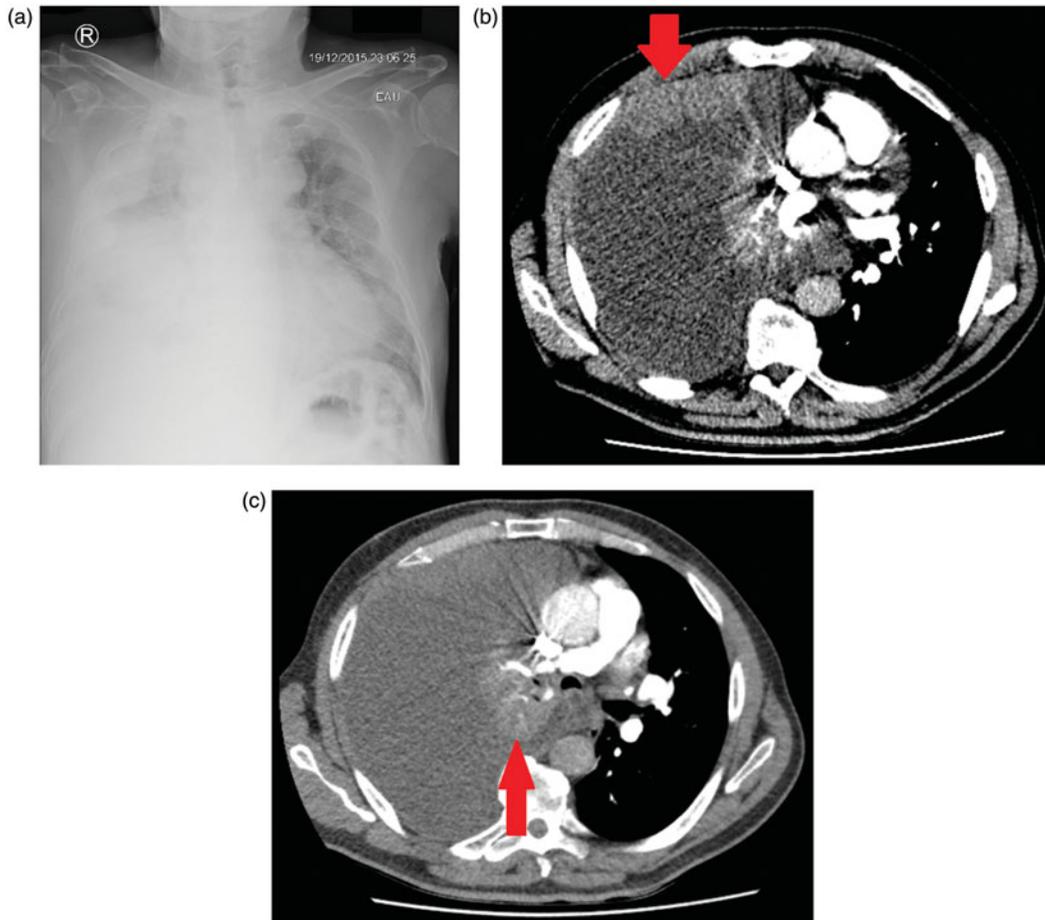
Pleural effusion associated with hilar mass and pleural metastasis. (a) Chest radiograph showing large right sided pleural effusion; (b) CT chest with contrast showing pleural metastasis (arrow); (c) CT chest showing right hilar mass (arrow).
